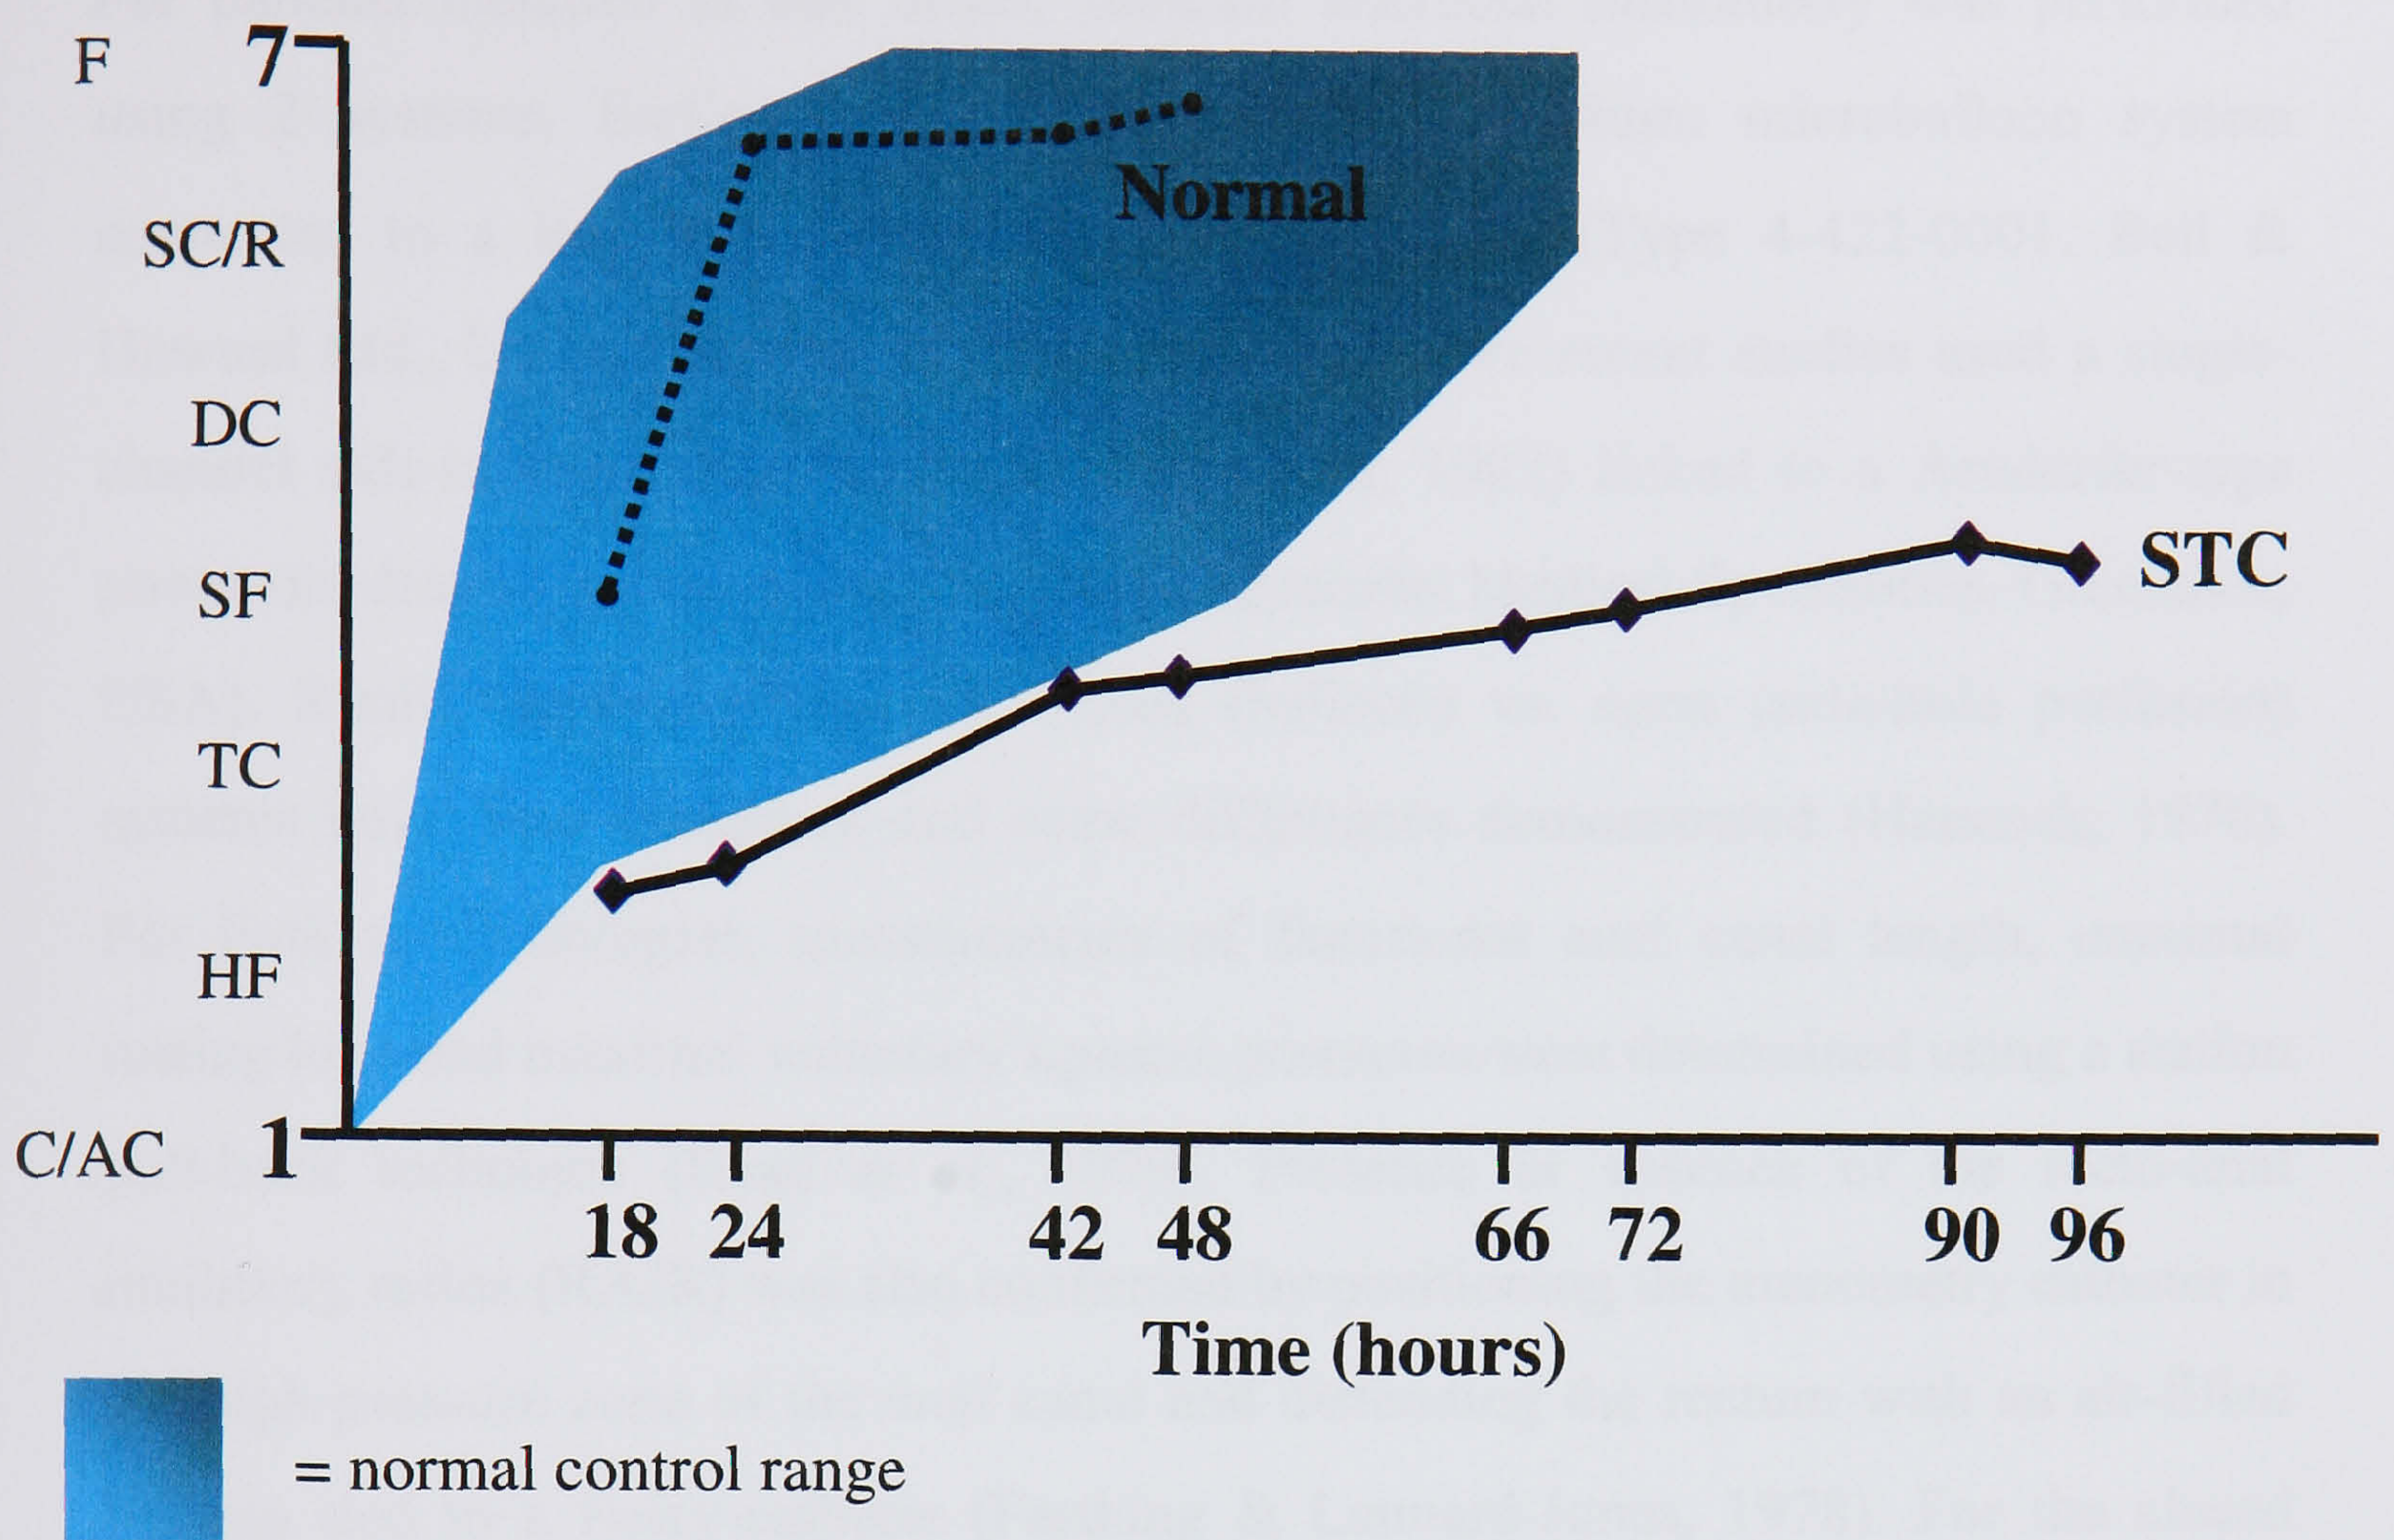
Isotope scintigraphic transit study. Progress of the geometric centre of isotope mass (GCI) through the colon with time. Seven regions of interest (ROIs) are defined:
